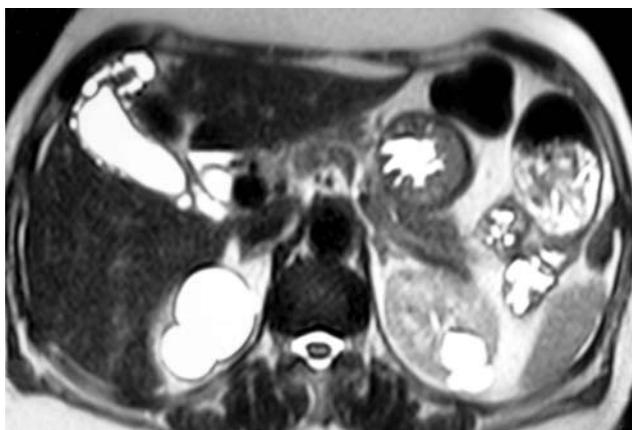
(a) Pre-meal and (b) post-meal axial HASTE MR images.
